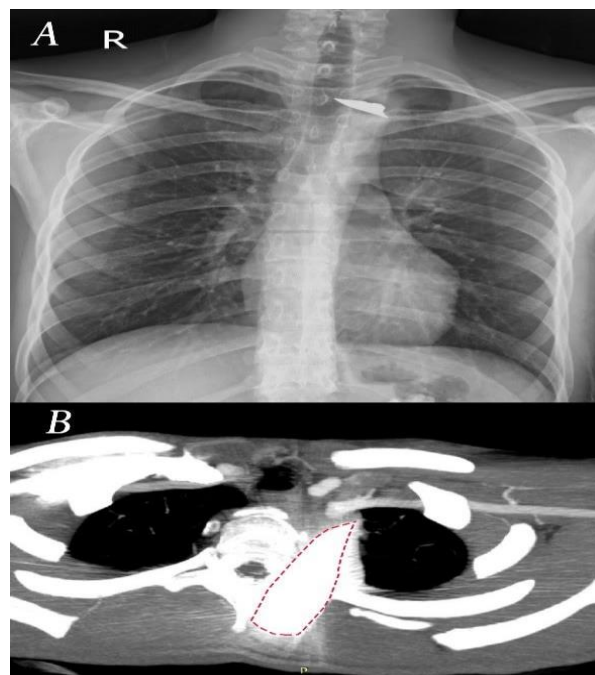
(A) Foreign body in chest x-ray, (B) Broken blade in computed tomography (CT) scan
